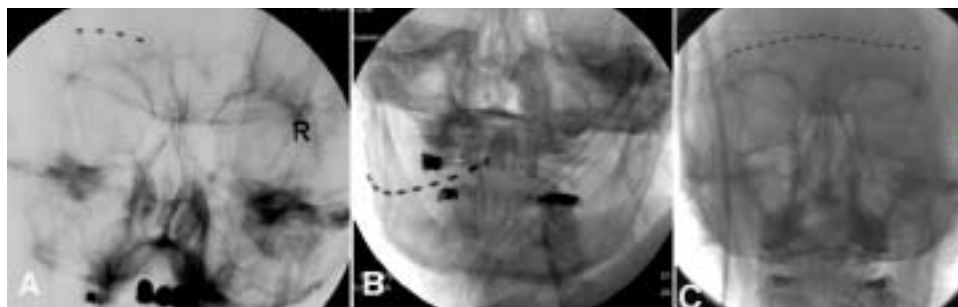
Radiographs showing positioning of electrodes. A: Unilateral four-contact supraorbital nerve stimulation electrode. B: Unilateral eight-contact occipital nerve stimulation electrode. C: Bilateral eight-contact supraorbital nerve stimulation electrodes.
